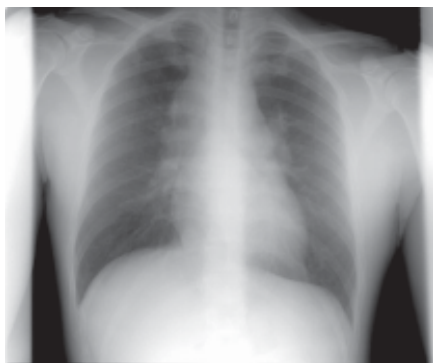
Chest radiograph shows widening of the paratracheal region.
